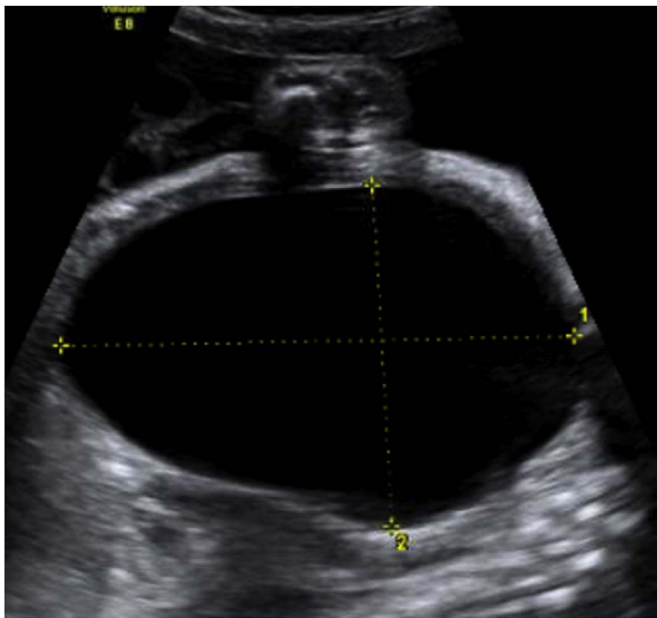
Prenatal ultrasound at 33 weeks showing severely dilated bladder measured at $9.6 \times 6.4 \times 7.7$ cm.
